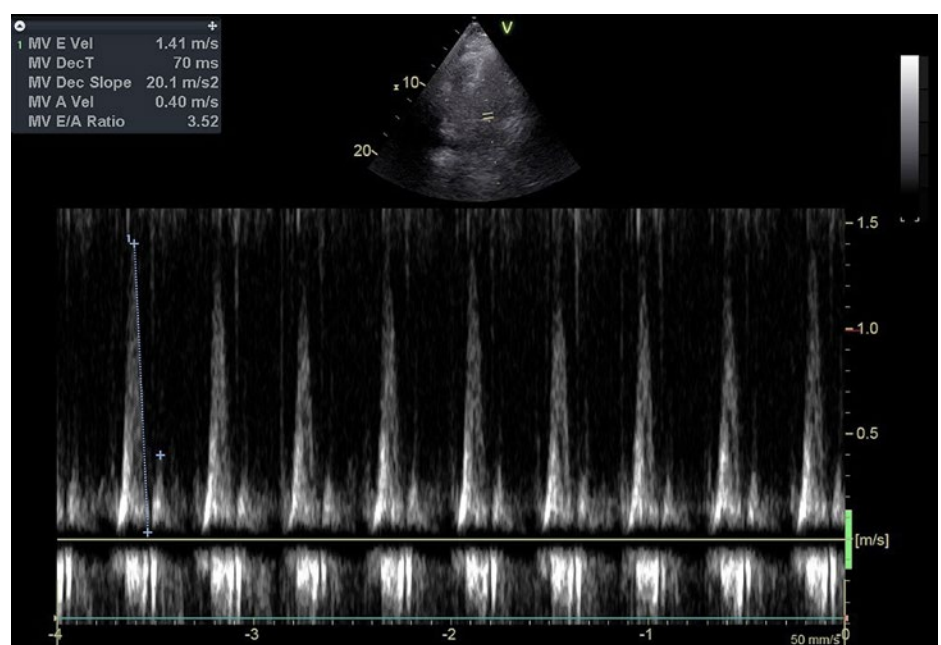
Transthoracic echocardiography showing acute diastolic dysfunction (mitral valve E/A ratio of 3.52). You will find a video file in the multimedia collection of Cardiovascular Medicine: <https://cardiovascmed.ch/online-only-content>.
